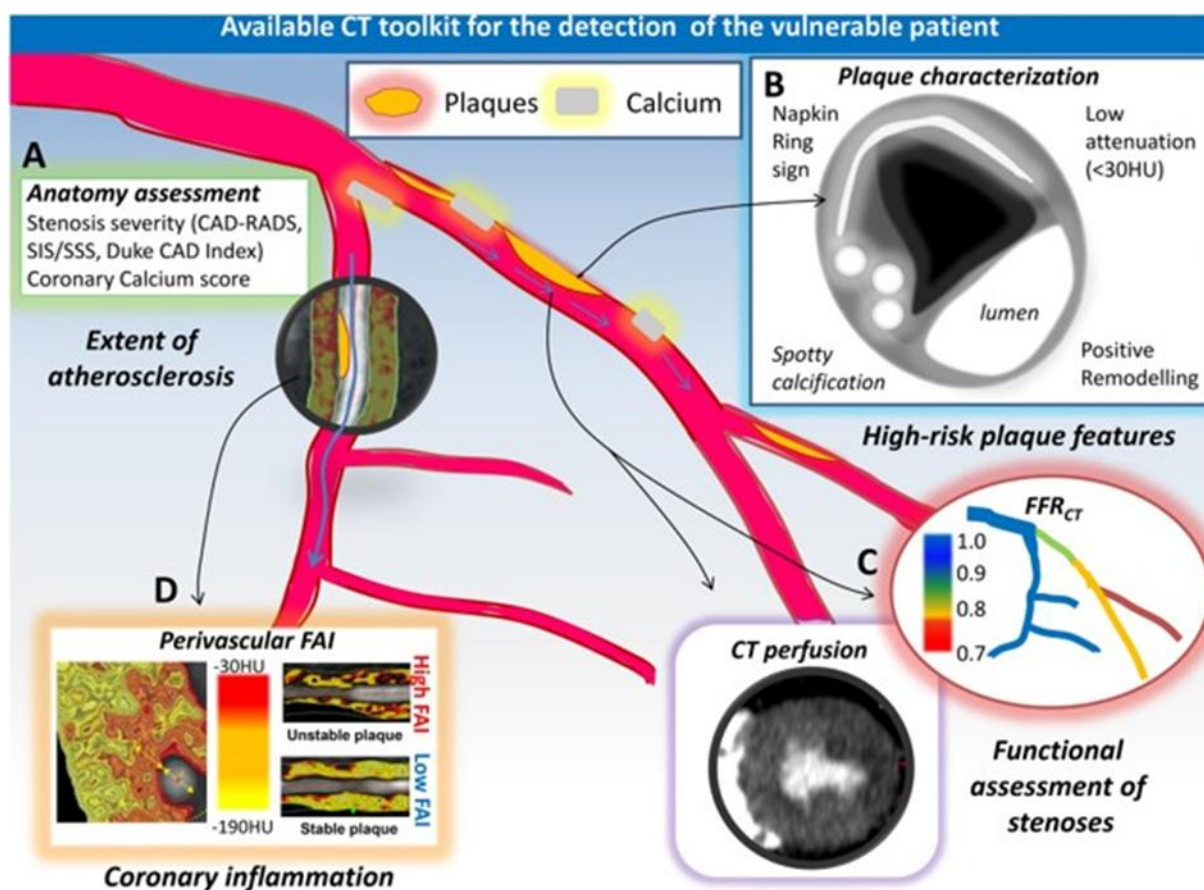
CT toolkit for the detection of the vulnerable patient (6).
